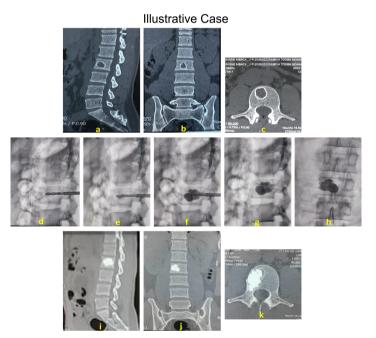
Solitary bone cyst of L2 in a 38-year-old man treated with vertebroplasty. CT scan of the lumbosacral spine in sagittal reconstruction. (a) coronal reconstruction; (b) and axial section; (c) before vertebroplasty. The vertebral body of L2 shows a rounded hypodense lesion with a hyperdense wall with regular contours corresponding to a benign-looking bone cyst of the vertebral body. Under constant scopic control, we introduce a working cannula (guide tube) with the guide tube and drill assembly into the vertebral body up to the cyst to take biopsy samples; (d) Start injection of bone cement with a cement injector; (e) Filling the cystic cavity with bone cement; (f) Removal of the injector and guide tube and lateral view; (g) Frontal scan at the end of the procedure; (h) CT scan with sagittal reconstruction; (i) coronal reconstruction; (j) and axial section; (k) after vertebrop-lasty showing good filling of the cystic cavity with bone cement.
